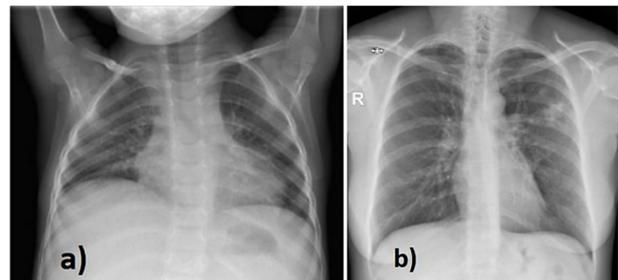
Thoracic X-ray: (a) Patient: normal X-ray appearance; (b) Mother: round opacity in the superior quarter of the left lung.
